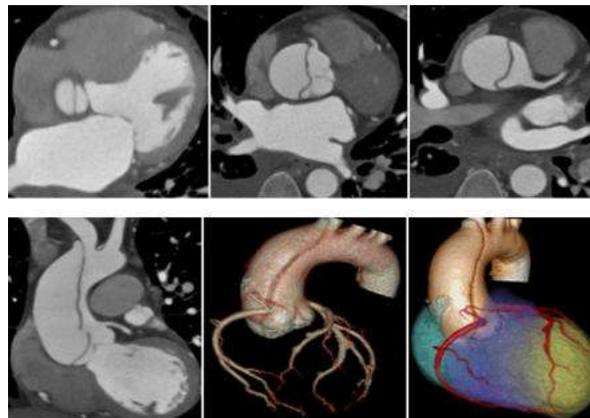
(A-F).Computed tomography coronary angiography (CTCA).Axial (A-C), reformatted Coronal (D), coronary tree and 3 D volume rendered images reveal aortic root & ascending aortic dissection (Debakey Type 2 / Stanford Type A). Normal origin of right and left coronary arteries from true lumen seen.
